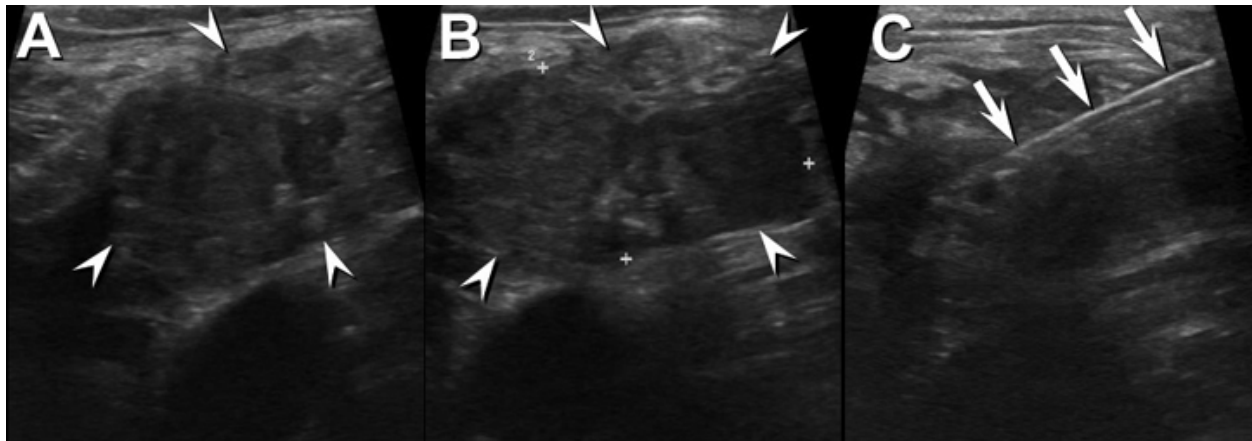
Transverse (A) and longitudinal (B) ultrasonographic images performed in the left base of neck, near the left supraclavicular region, shows a hypoechoic mass (arrowheads; also marked by calipers in [B]) correlating with the physical examination findings and  $^{18}\text{F}$ FDG-PET scan abnormalities. Ultrasound-guided percutaneous biopsy (C) of this mass was performed; note presence of needle (arrows) within the mass.
